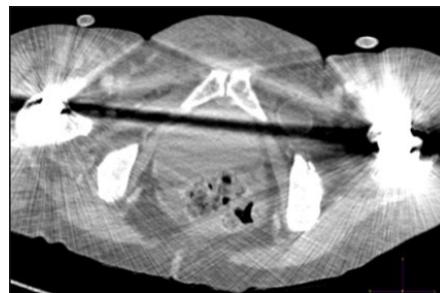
axial CT pelvic image showing the small bowel loop descending into the left obturator canal with bilateral hip prosthesis.
